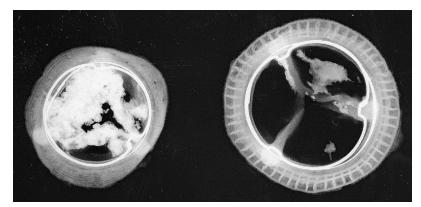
Radiograph of the bioprostheses excised from the aortic valve position (*left*) and the mitral valve position (*right*). The calcific deposits are huge on the left and small on the right.
